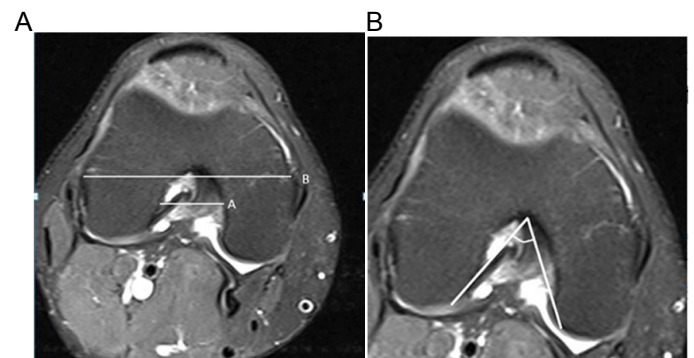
A) Axial PD (Fat Sat) MRI demonstrating measurement of femoral NWI. A Femoral notch width B Intercondylar width.  $NWI = A/B$ , B) Axial PD (Fat Sat) MRI demonstrating notch angle measurement.
